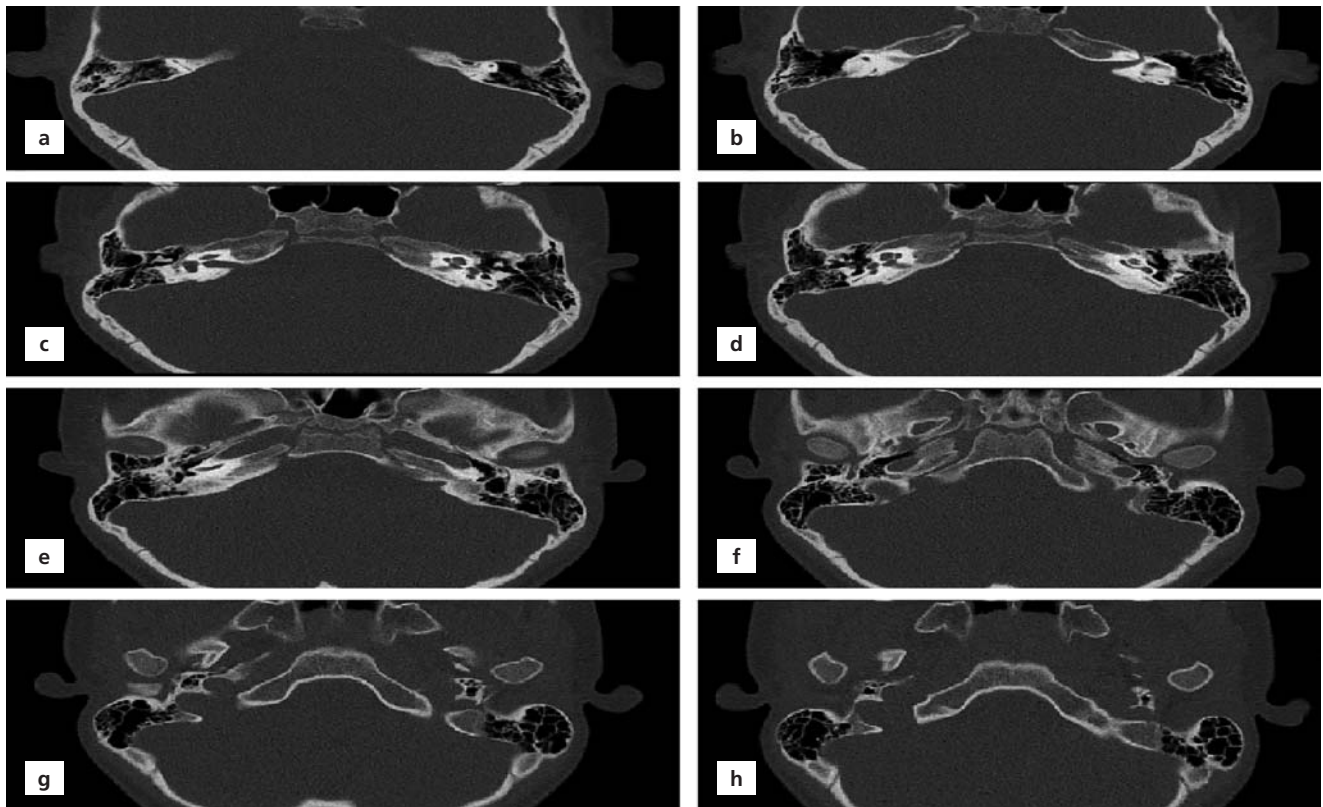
Axial thin-section CT scans (a–h). The continuity of the atresia of the external acoustic meatus can be followed in sequential sections.
